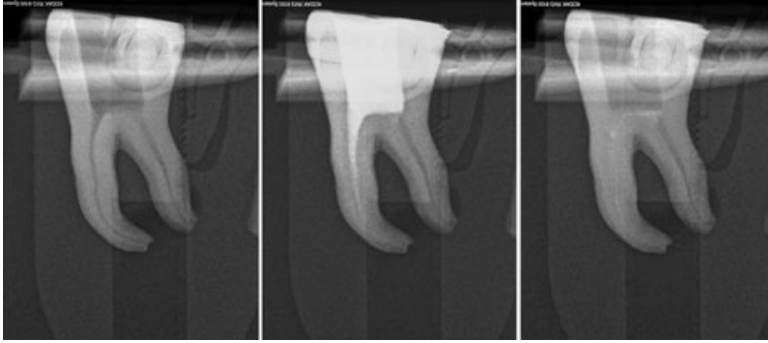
Example of preoperative, active and passive irrigation radiographs.
